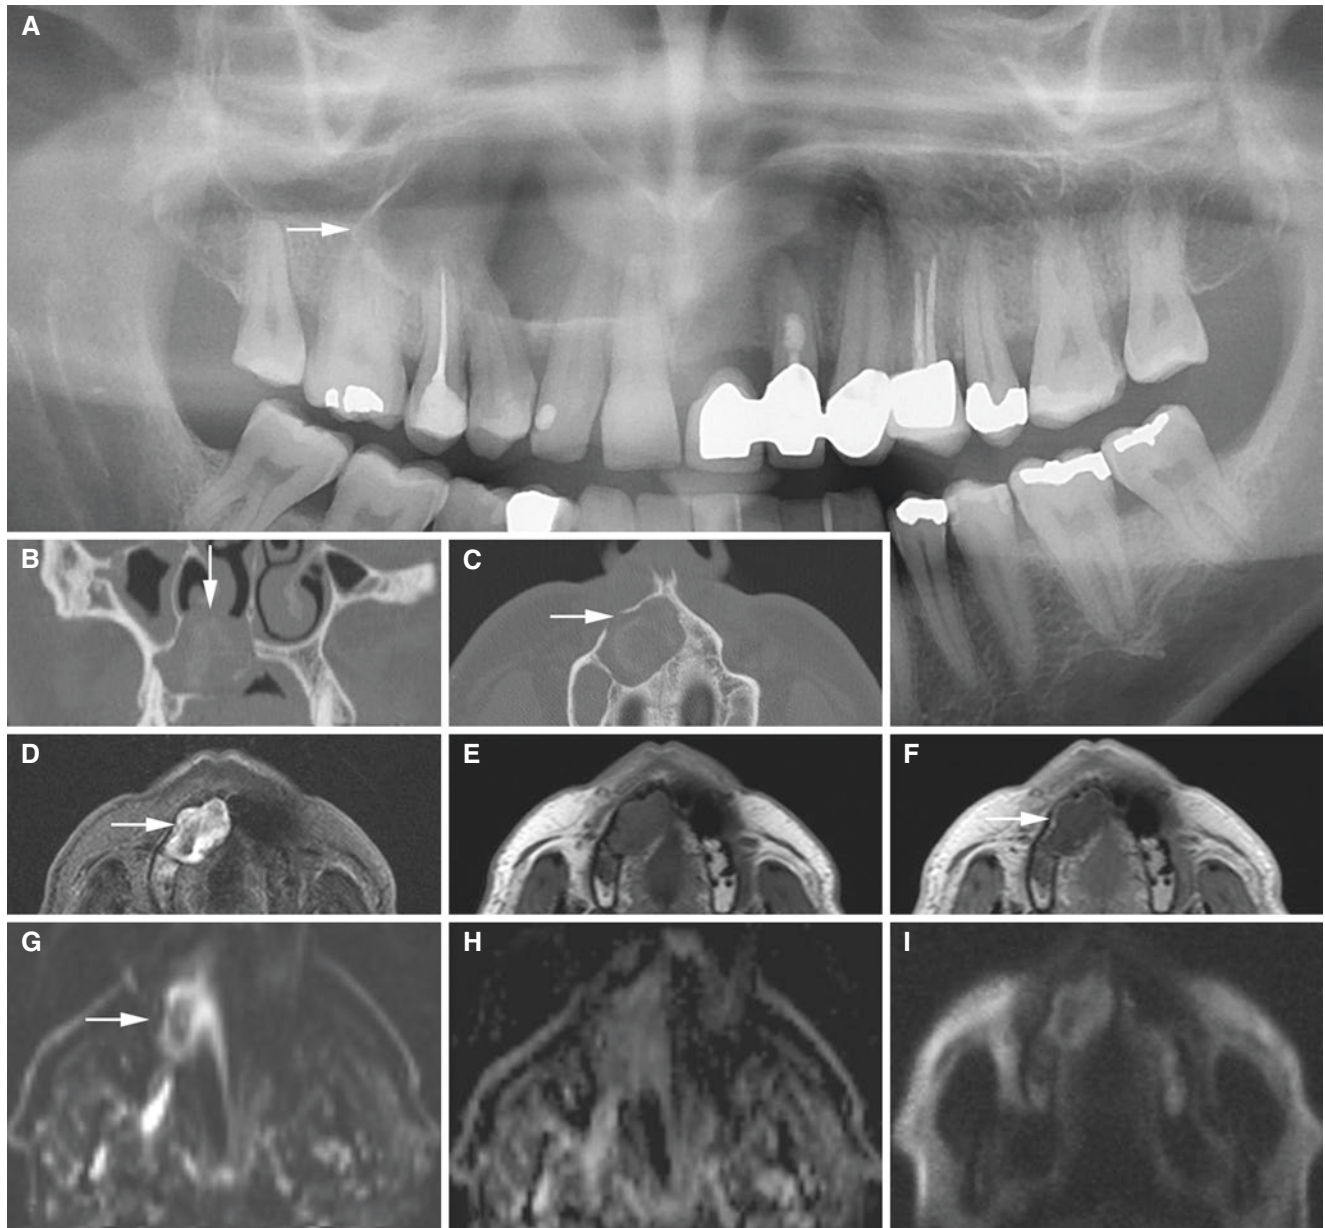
Keratocystic odontogenic tumor, maxilla; 48-year-old male with swelling in anterior part of the right hard palate. (A) Panoramic view shows radiolucency with corticated outline (*arrow*). (B) Coronal and (C) axial CT images show well-defined, expanding radiolucency with cortical defects (*arrow*). (D) Axial T2-weighted MRI shows
